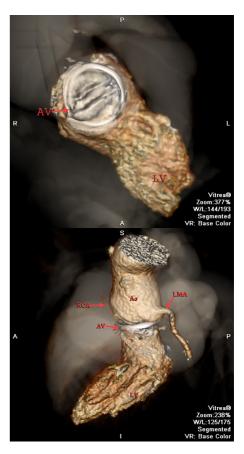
Chest computed tomography scan. A. Absence of vegetations at the leaflets of prostheses. B. Absence of vegetations at the ascending aorta and the basement of aorta
